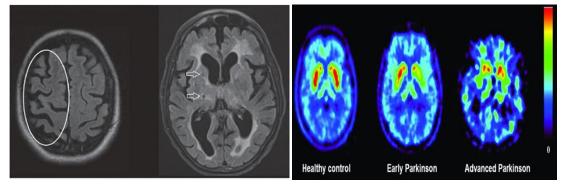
Parkinson's MRI brain & SPECT
